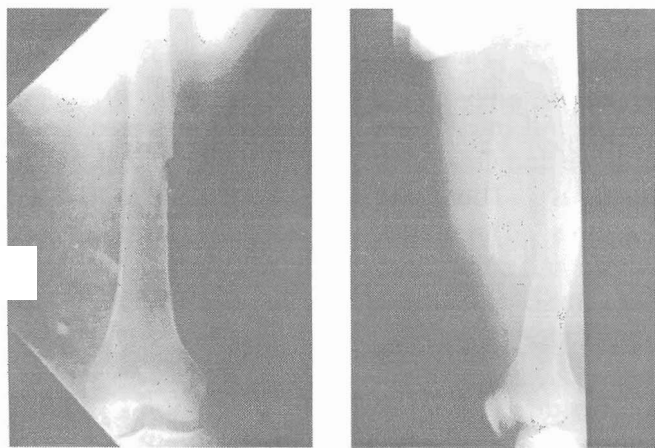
Radiographs of 30-year-old patient with transverse fracture of the shaft of the left femur; (a) anterior-posterior; (b) lateral views.
